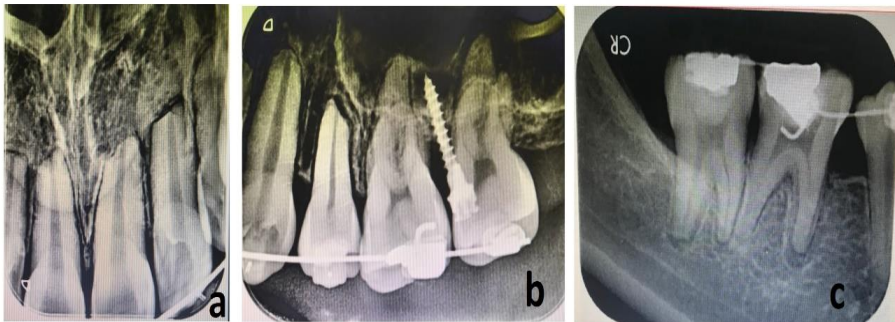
Intraoral periapical radiographs of maxillary incisors (a), maxillary left posterior teeth (b), and mandibular right posterior teeth (c).
